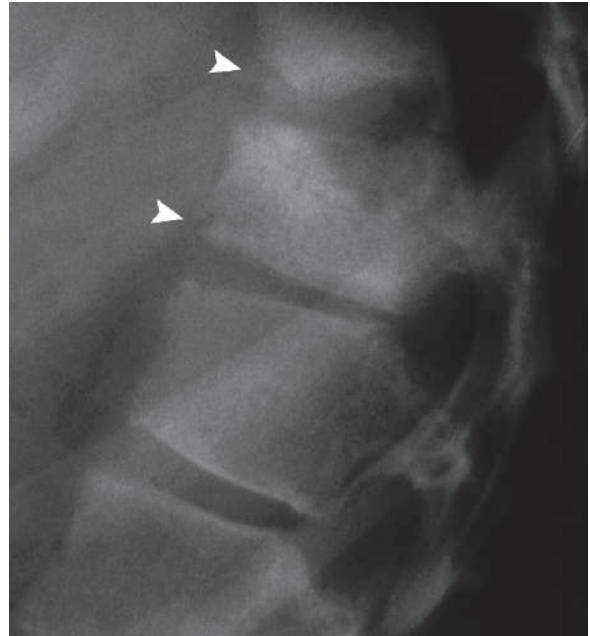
Lateral plain radiograph of the thoracic vertebrae in a patient with a history of previous typhoid fever infection who presented with erosions of the inferior end plates due to typhoid osteomyelitis (*arrowheads*)
